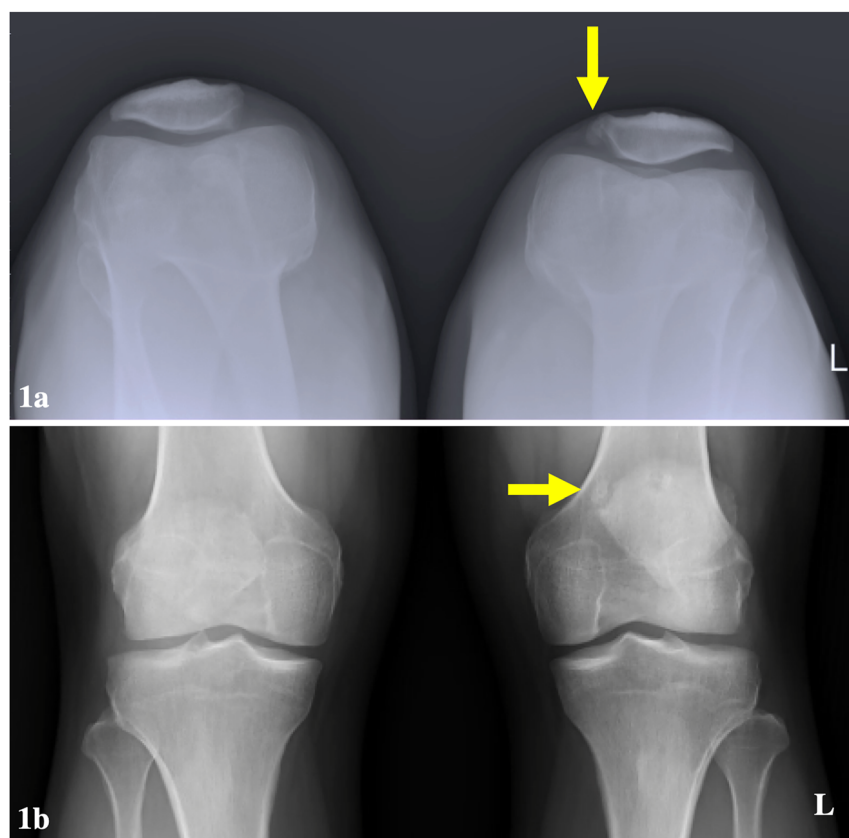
Plain-film radiograph images suggested that a fragment of 0.5 cm in width and 0.9 cm in length was found at the superior-medial pole of the patella in the left knee (yellow arrow). (A) Merchant view, and (B) anterior-posterior view.
